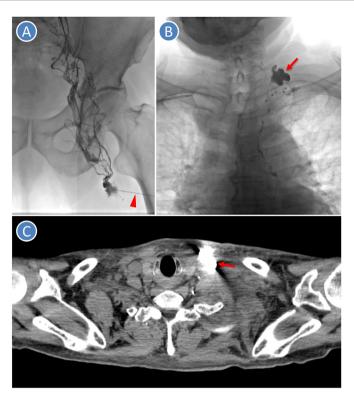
Ultrasound-guided intranodal lymphangiography with lipiodol and computed tomography images for our patient with chyle leak after neck dissection. (A) Ultrasound-guided lipiodol injection was performed from a left inguinal lymph node. (B) A leak site (arrow) over the left supracervical region with contrast extravasation was identified. (C) Computed tomography showed the left cervical leak site (arrow) after lipiodol lymphangiography.
